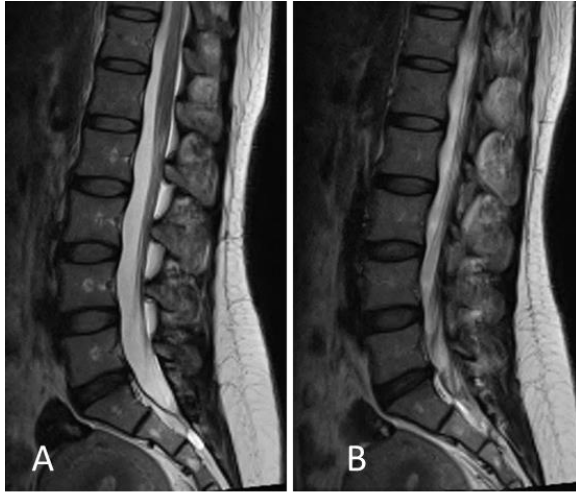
Magnetic resonance imaging of patient 1. Representative sagittal T2 weighted signal of L5/S1 IVD before operation (A) and 12 months after operation (B). There were no significant changes in normalized T2 values of both nucleus pulposus and annulus fibrosus tissues.
